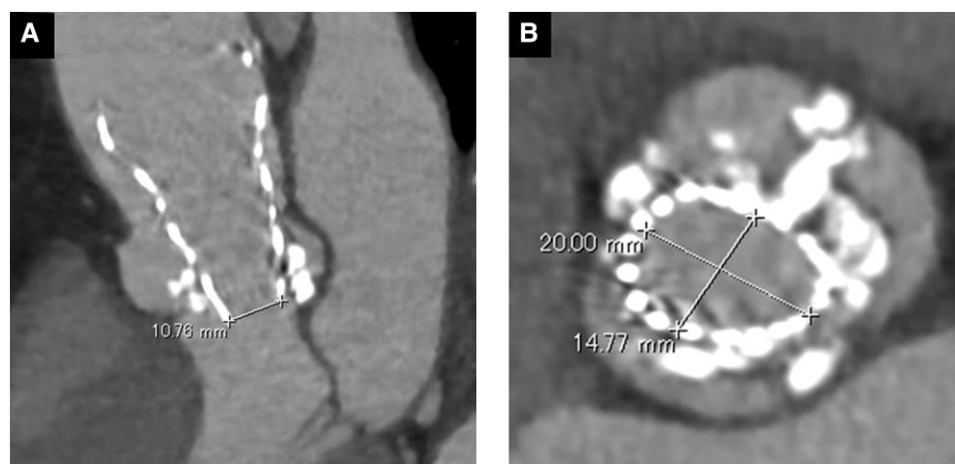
Cardiac computed tomography following the transcatheter aortic valve implantation procedure. Cardiac computed tomography reveals a self-expandable prosthetic valve with flattened spreading. (A) Coronal axis view. (B) Axial view.
